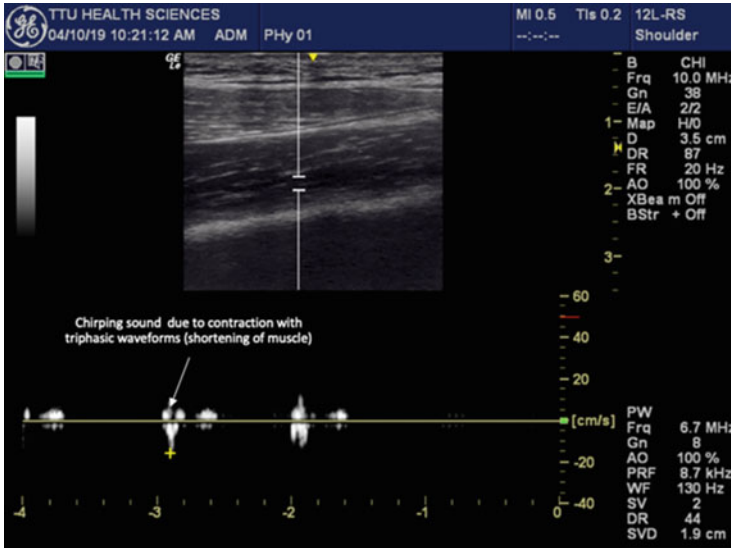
Doppler mode: insonating the vastus intermedius in the longitudinal view; a chirping sound with biphasic or triphasic waveform which can be seen and heard in the video Fig. 11.18
